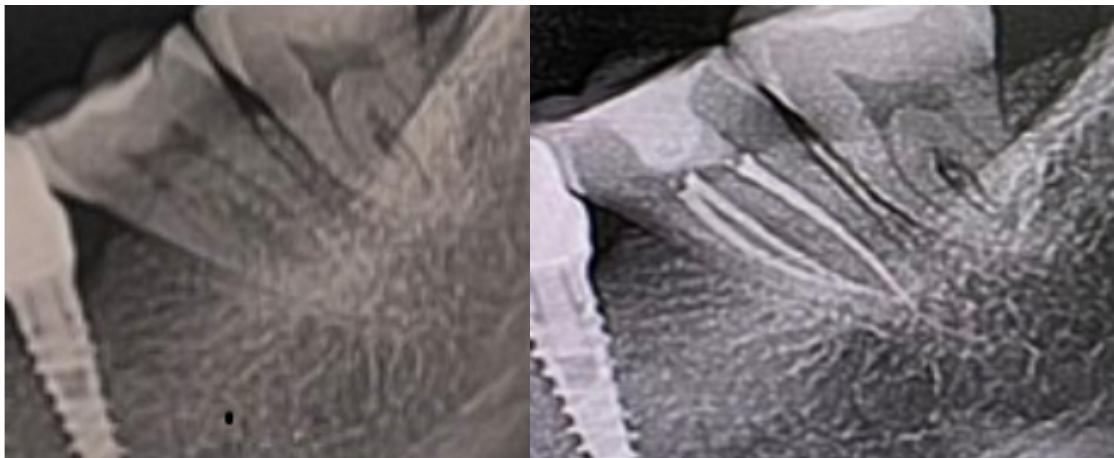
Preoperative and postoperative retroalveolar radiograph of tooth 37
